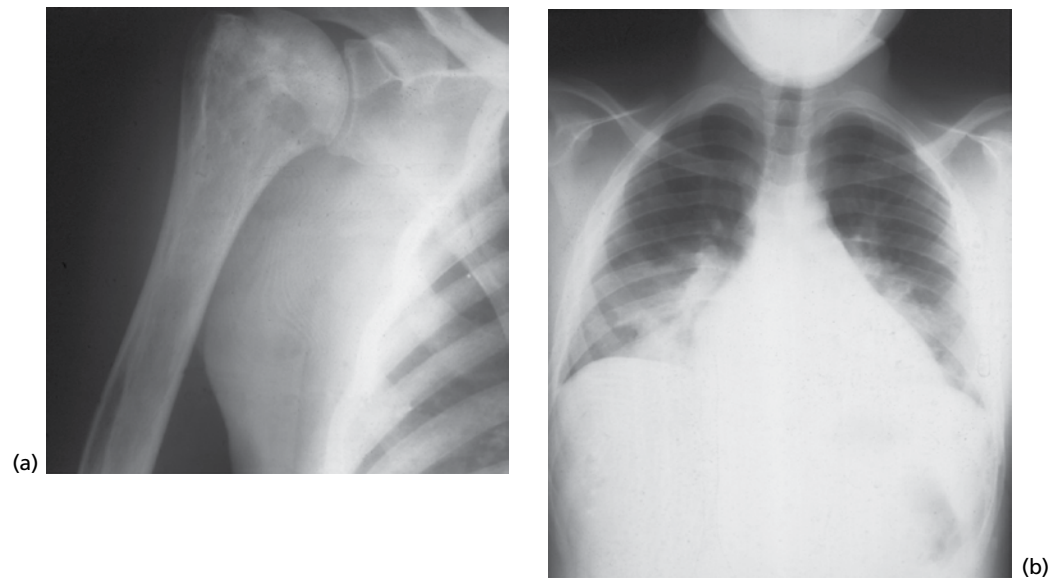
Radiography in sickle cell anaemia: (a) radiograph of the head of the humerus showing areas of reduced radiodensity, consequent on previous infarction; (b) chest radiograph showing opacities in the lower half of both lung fields representing pulmonary infarction as a result of sickle cell formation and vascular occlusion. (With thanks to Professor Irene Roberts, Oxford and London.)
